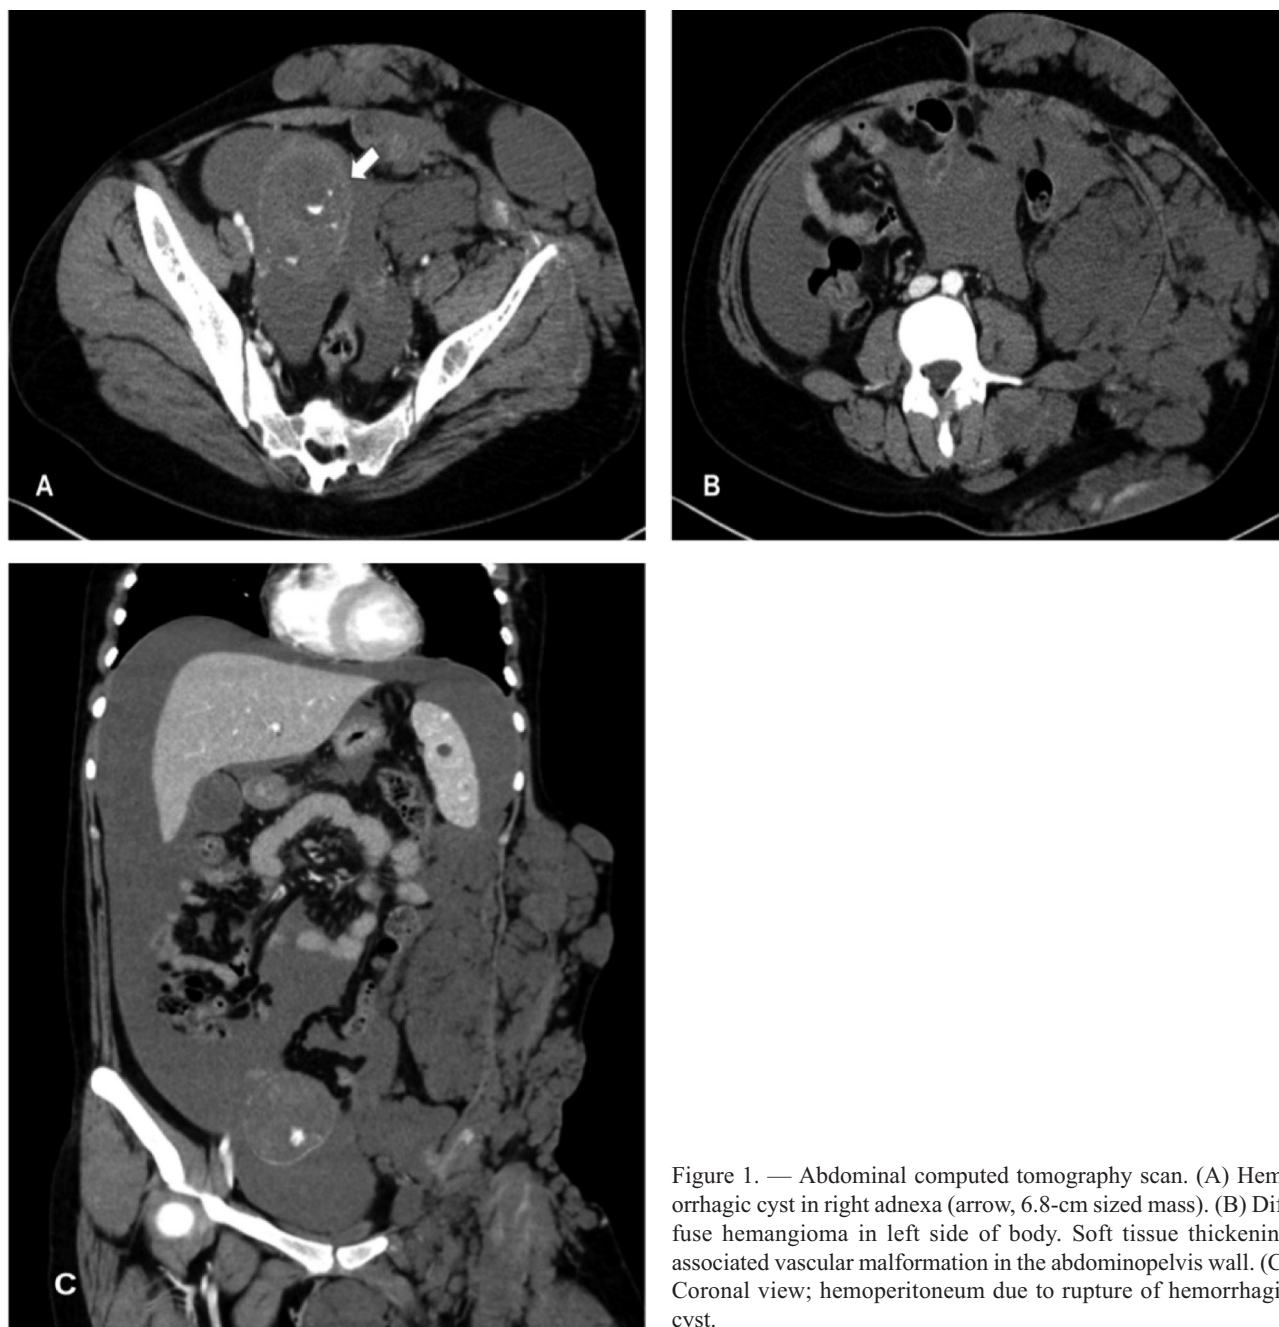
Abdominal computed tomography scan. (A) Hemorrhagic cyst in right adnexa (arrow, 6.8-cm sized mass). (B) Diffuse hemangioma in left side of body. Soft tissue thickening associated vascular malformation in the abdominopelvis wall. (C) Coronal view; hemoperitoneum due to rupture of hemorrhagic cyst.
